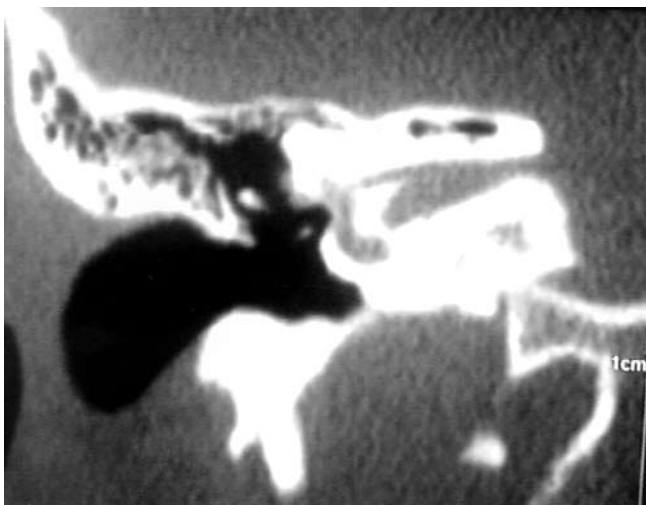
Axial CT section of right ear showing superior vestibular nerve canal enlargement.
